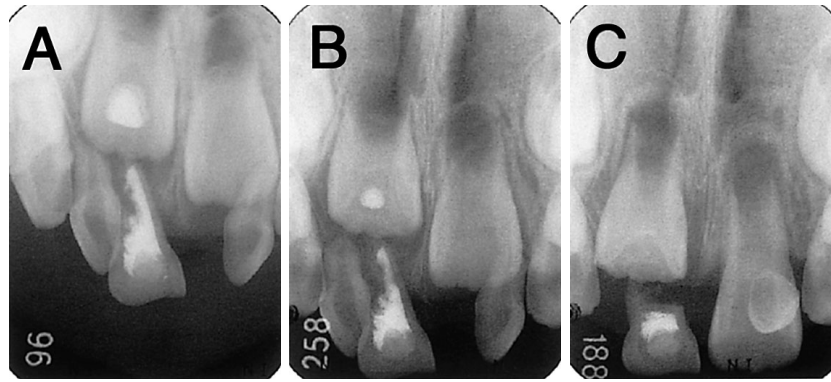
Periapical radiograph taken at 5Y2M (A), 5Y6M (B) and 6Y8M (C) in Case 2
